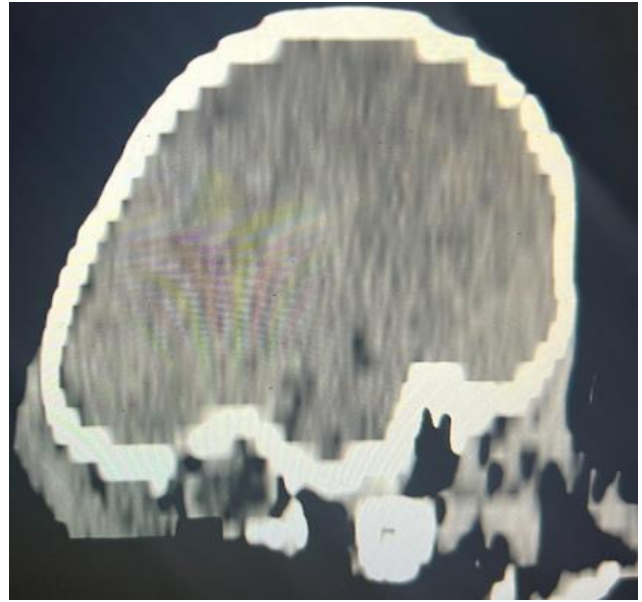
Sagittal view CT scan showing right fronto-orbital isodense mass.
